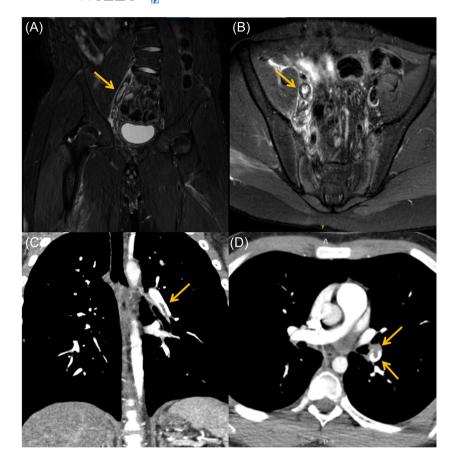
Imaging confirmation of VTE. Coronal (A) and axial (B) fat-suppressed T2weighted images of MRI scan of right hip joint, demonstrating a hyperintense clot in the right external iliac vein, and coronal (C) and axial (D) views of lung CTPA scan revealing a large pulmonary embolus of approximately 3 cm longitudinal diameter in left pulmonary artery's branch which supplies the left lower lobe. CTPA, computed tomography pulmonary angiogram; MRI, magnetic resonance imaging; VTE, venous thromboembolism. [Color figure can be viewed at wileyonlinelibrary.com]
